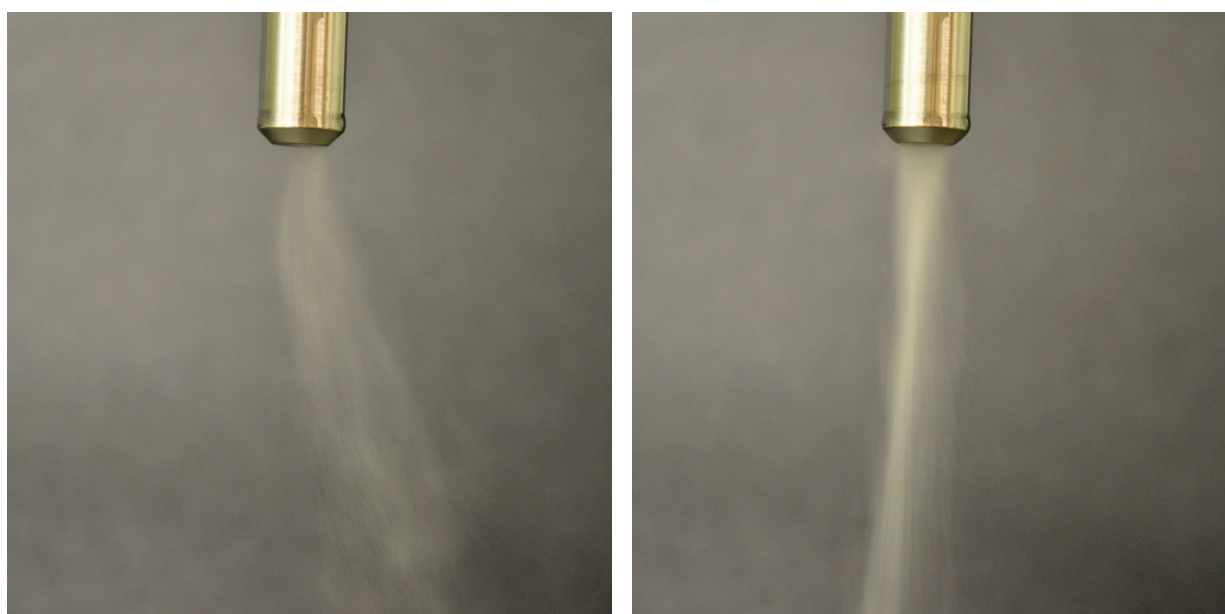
Tapped horn spray in air. Sonospray of ethanol passed through tapped 20 kHz ultrasonic horn at 30% power. Left: ethanol flowing at 3.3 ml/min. Right: ethanol flowing at 12.7 ml/min.
